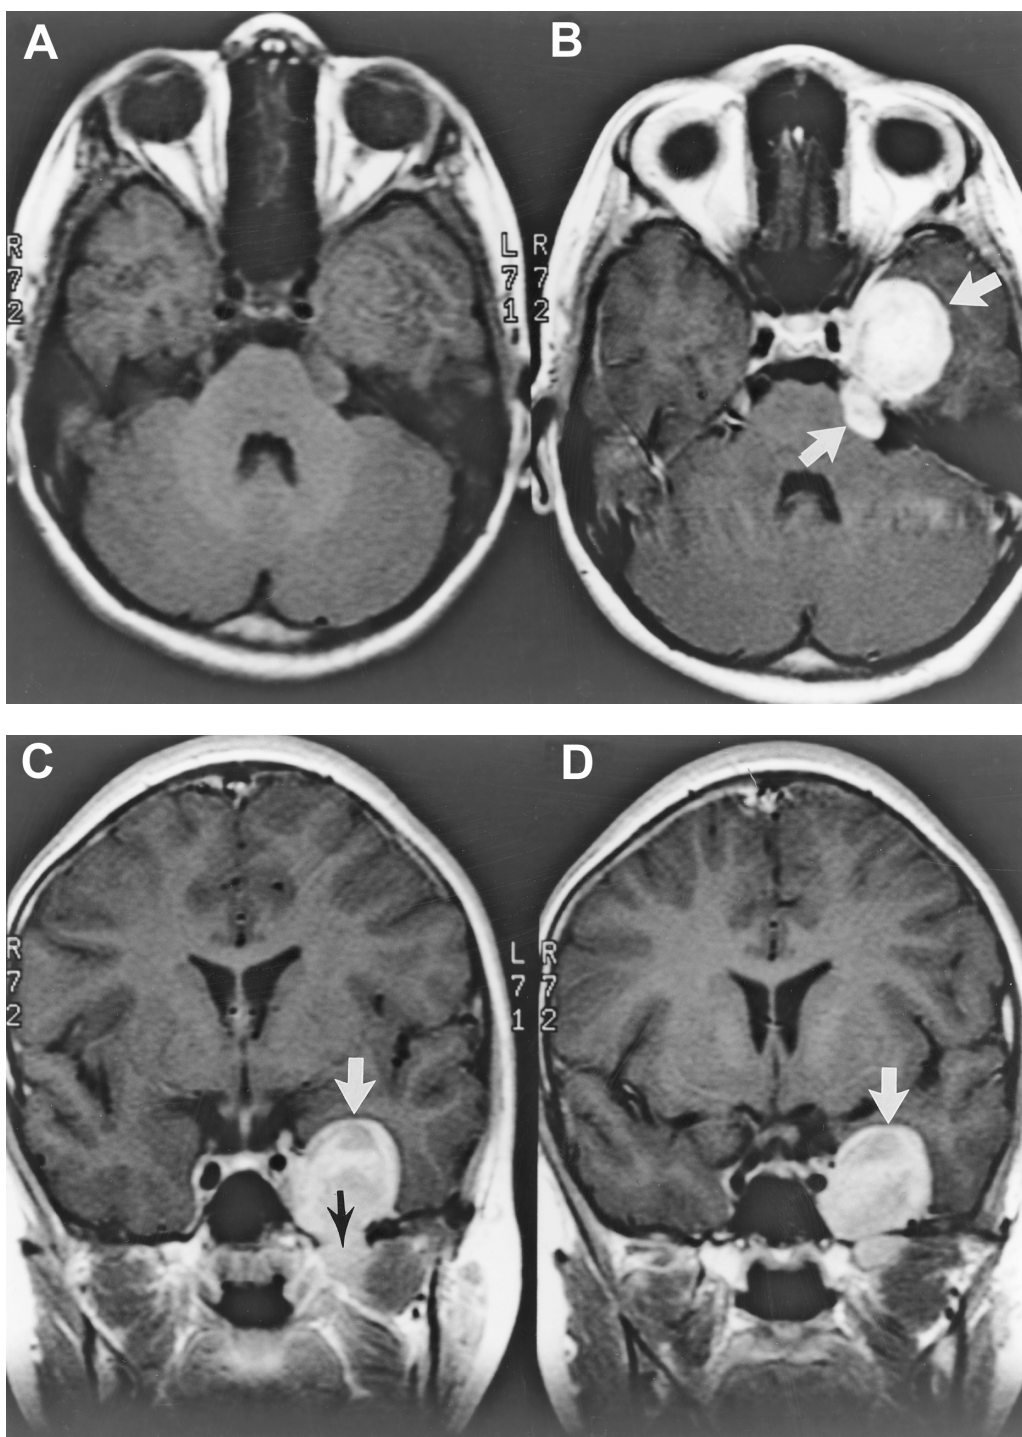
Trigeminal schwannoma. Pre-contrast axial (A), post-contrast axial (B), and coronal (C,D) MRI scans. A well-defined enhancing mass (arrows in B, C, and D) is seen along the course of the trigeminal nerve. A small portion of the tumor projects below the skull base enlarging the foramen ovale (black arrow in C).
